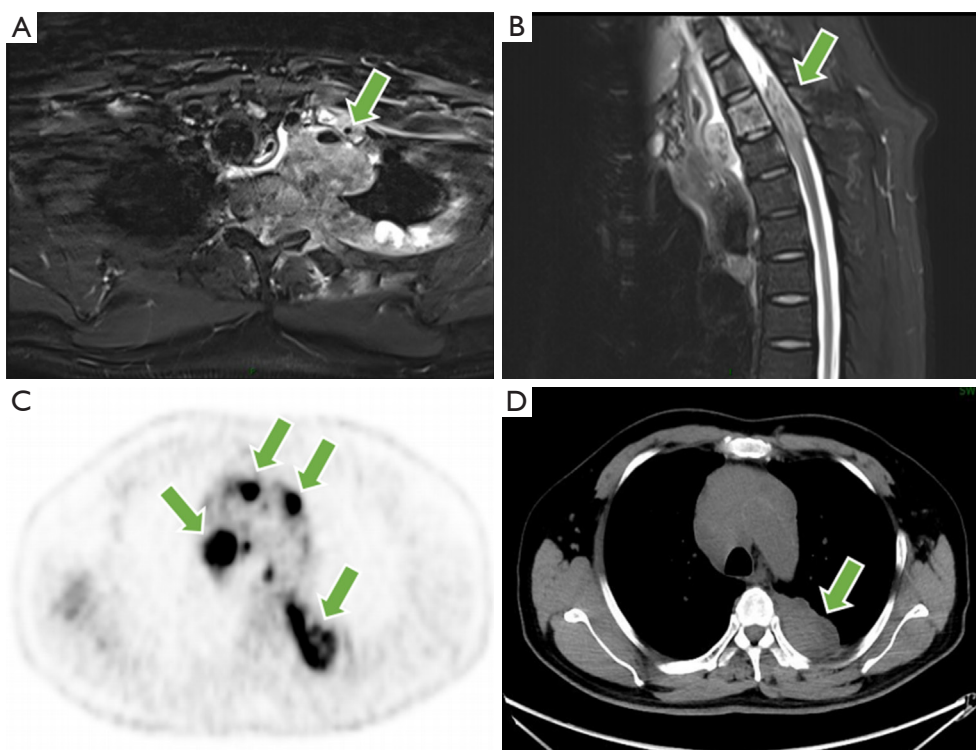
MRI and ^{18}F -fluorodeoxyglucose PET/CT images of the mediastinal masses. (A) MRI T2-weighted image shows multiple cervicothoracic, mediastinal, and pleural masses fused (green arrow). (B) The mass encircles the surrounding blood vessels and invades the vertebral body, and the T2 and T3 vertebrae correspond to spinal stenosis and spinal cord compression (green arrow). (C) PET/CT shows increased multiple uptakes in the mediastinum and left hilum (green arrows). (D) CT image of the elevated area corresponding to the posterior mediastinal mass was taken (green arrow). MRI, magnetic resonance imaging; PET/CT, positron emission tomography/computed tomography; CT, computed tomography.
